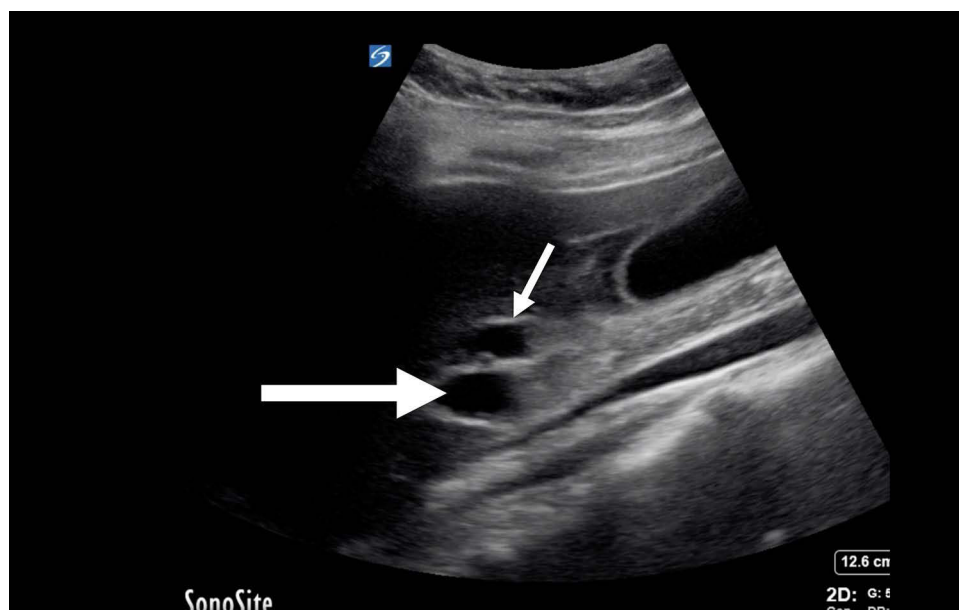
Sonographic appearance of a dilated common bile duct. Large arrow represents portal vein. Small arrow represents common bile duct.
